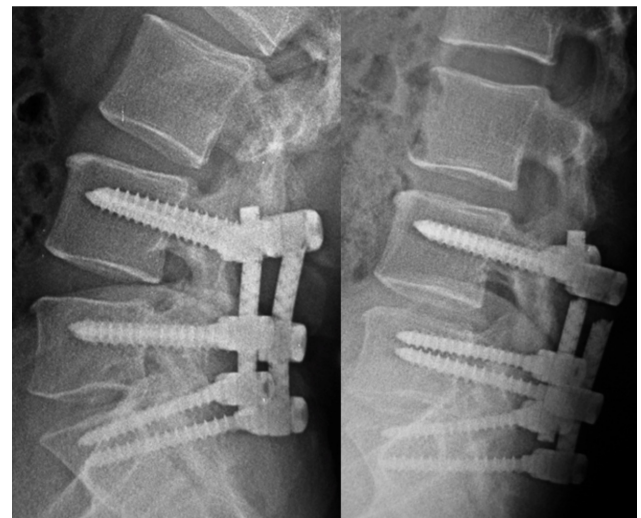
A 53-year-old male patient who was operated for lumbar stenosis. On the 38th month follow-up radiographs, it is observed that the dream rod is broken
